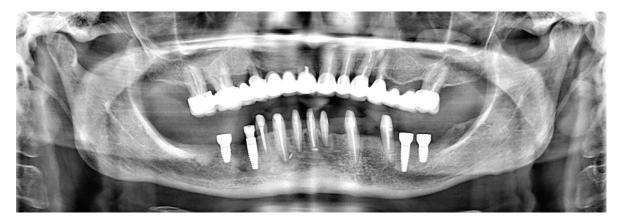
Panoramic X-ray obtained before prosthetic phase of treatment
